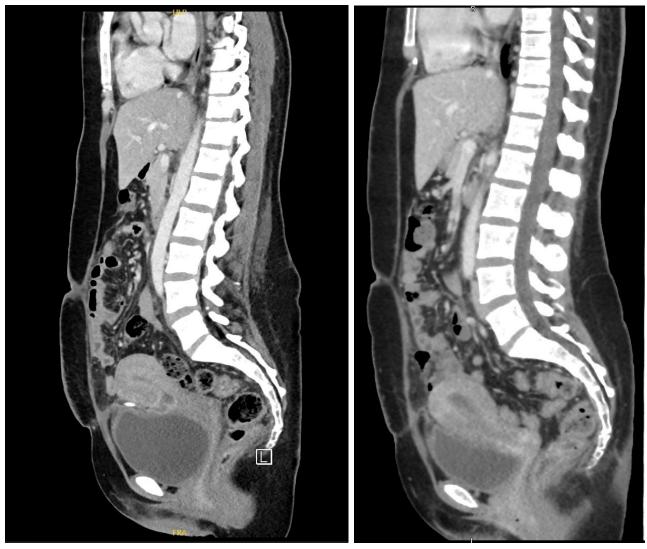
CT abdomen and pelvis done on day 15 of admission showing interval resolution of the collections
